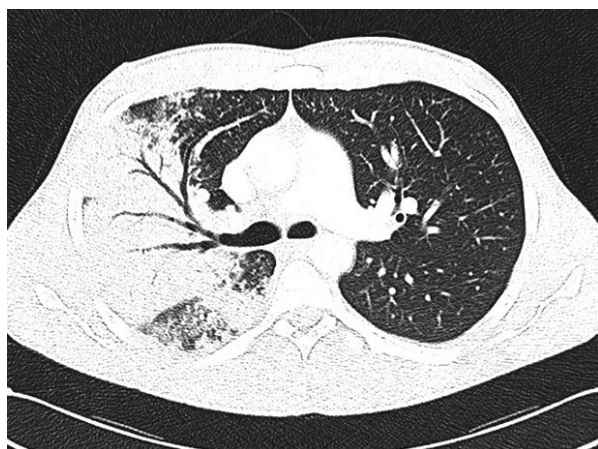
Chest computed tomography (CT). Massive infiltrations in peripheral parts of the right upper lobe with prominent air bronchogram of all segmental bronchi
